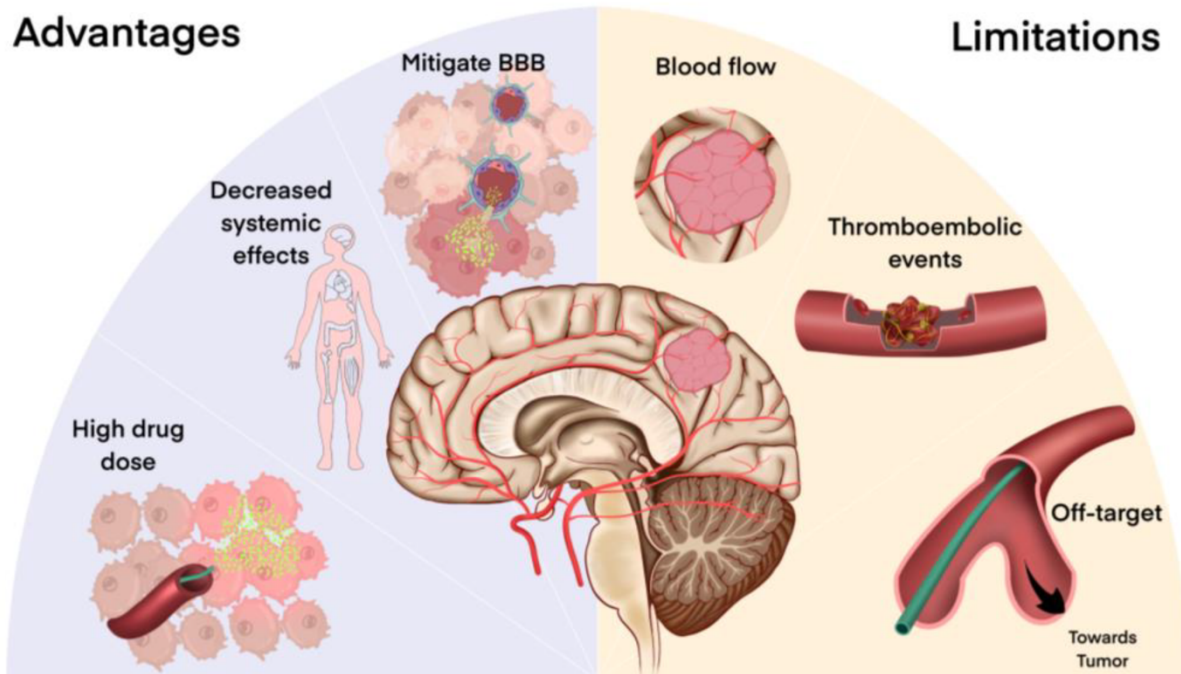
Overview of high-grade glioma super-selective cerebral arterial infusion (SSIAI) benefits and drawbacks. Local endovascular drug administration reduces systemic effects, allowing high doses of medications to be delivered directly to the tumor bed. Direct endovascular delivery may allow BBB disruptors such as focused ultrasound to be administered simultaneously.
